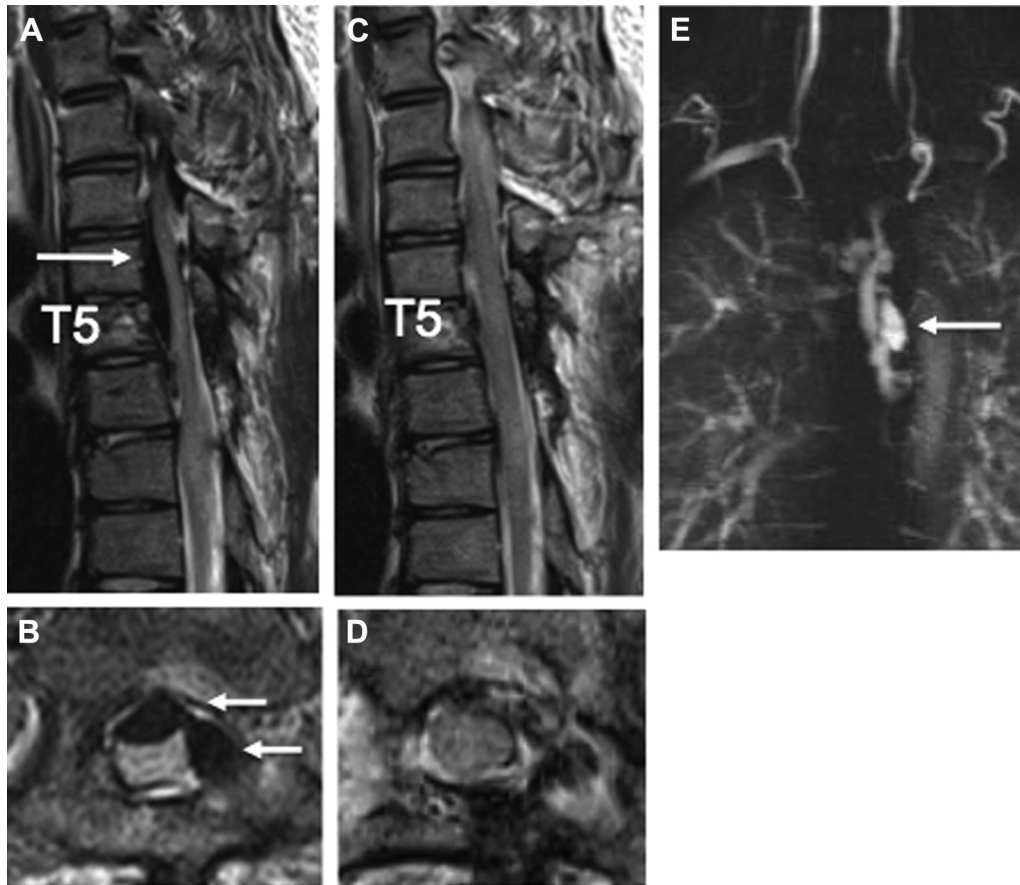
Magnetic resonance images of the lower cervical and thoracic spine (A, B) before and (C, D) after multiple sessions of endovascular intervention. (A, B) T2-weighted sagittal image (A) showing a newly emerged, low-intensity mass compressing the spinal cord at T4 and T5 levels (arrow) when the patient presented with myelopathy. “T5” indicates the vertebral level. An axial image of the (B) T5 level demonstrating a distorted spinal cord and intramedullary T2-hyperintensity. Note the enlarged venous structure compressing the ventral and left lateral spinal cord (arrows). (C, D) Sagittal (C) and axial (D) T2-weighted images confirmed the decrement of the epidural venous plexus and decompression of the spinal cord. (E) Magnetic resonance angiogram demonstrating the remnants of the arteriovenous shunt and venous pouch (arrow).
